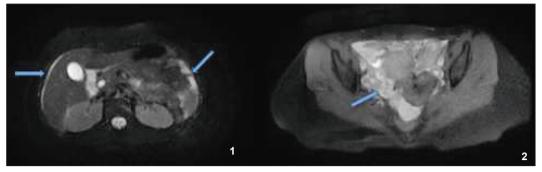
Abdominal MRI: Common peritoneal involvement of the liver.
